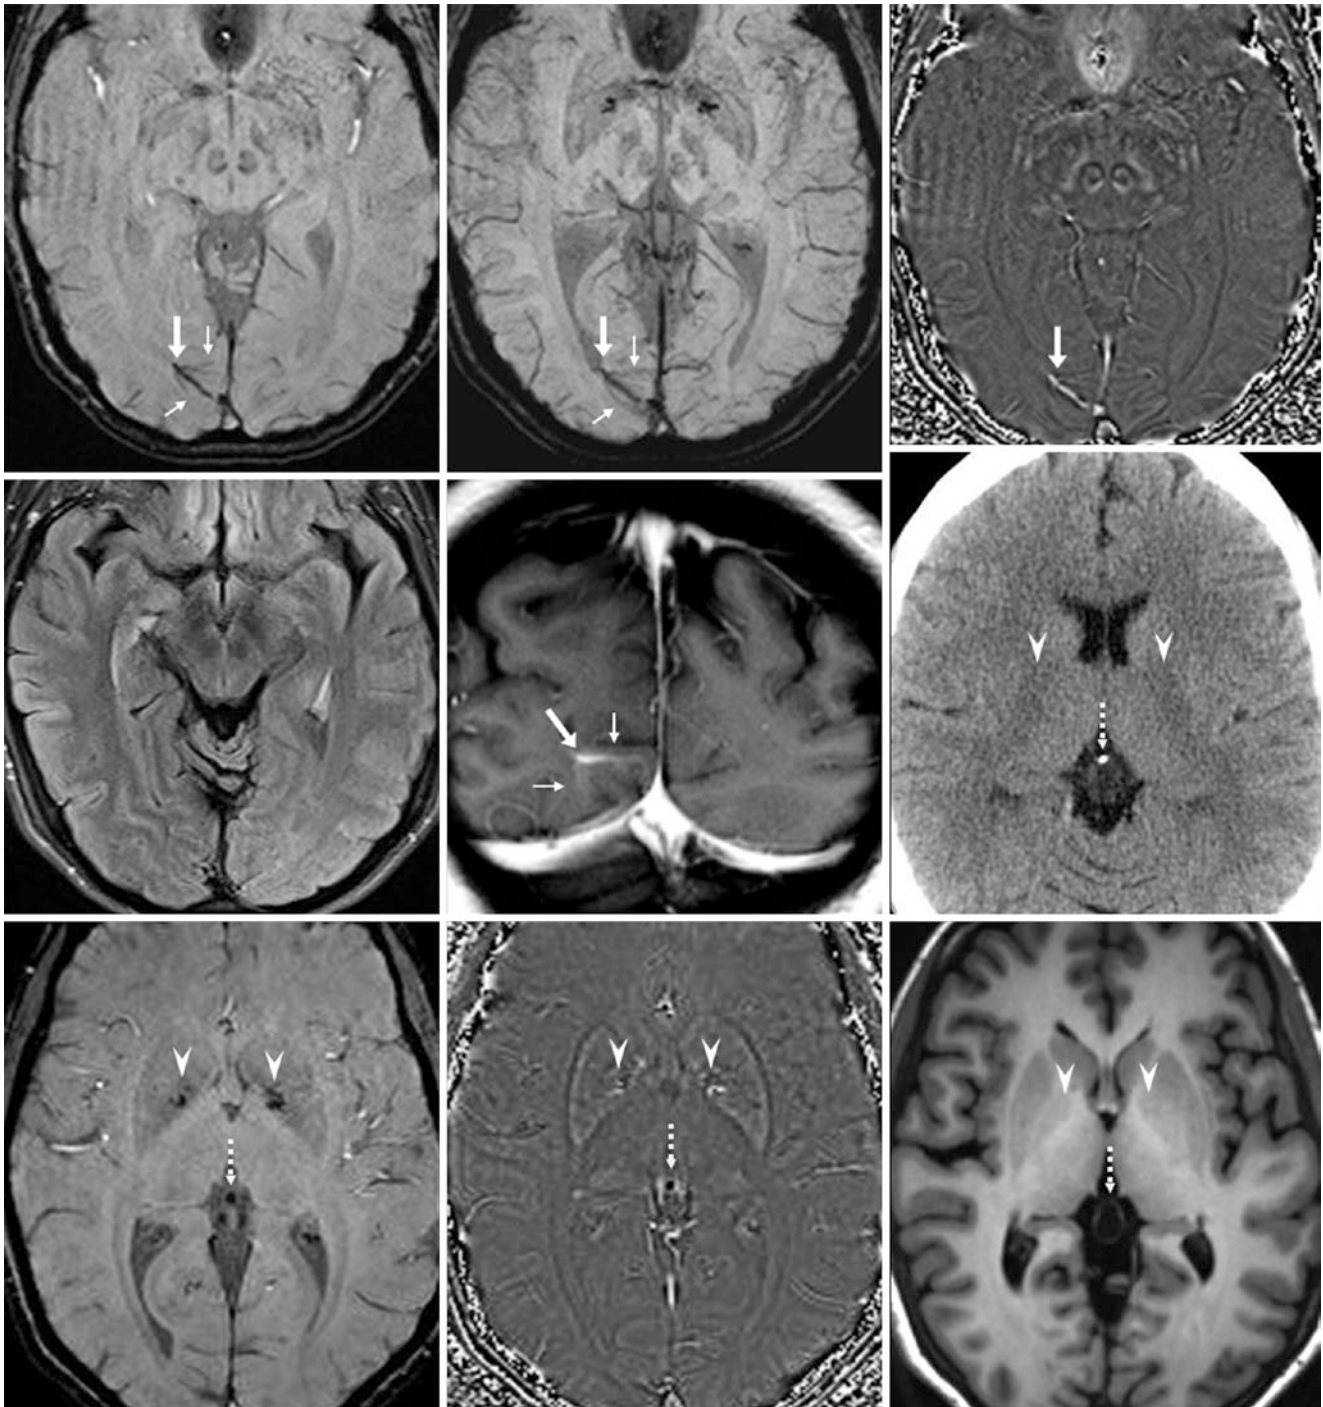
A 55 year old with breast cancer in whom a left-handed 3T MRI was negative for metastases. *Top row:* 2-mm-thick SWI (*left*) depicted a draining vein (*arrows*) from a DVA, with as faint caput" (*thin arrows*), also shown on a 10-mm MIP (*middle*). The phase map (*right*) demonstrates bright signal from paramagnetic deoxygenated blood. *Middle row:* an axial postcontrast FLAIR image (*left*) does not demonstrate the DVA as well as coronal postcontrast SE T1WI (*middle*). On axial NECT (*right*), there is a pineal calcification (*dotted arrows*) within a pineal cyst. On NECT, note the lack of calcifications within the globi
